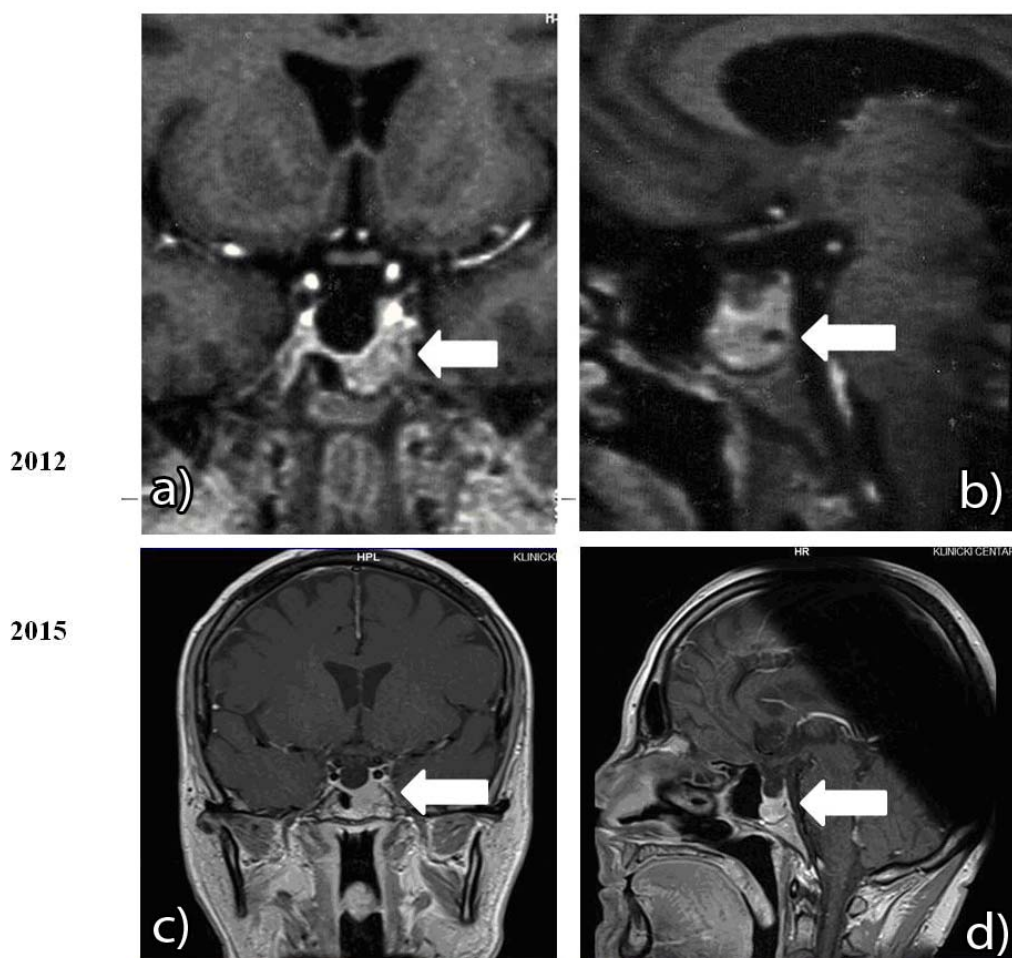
Magnetic resonance imaging (MRI) of sellar region shows empty sella configuration but with expansive parasellar mass and infrasellar propagation at the time of diagnosis [a – coronal (frontal), b – sagittal view] and with a slight regression of the changes 3 years later (c – frontal, d – sagittal view).
